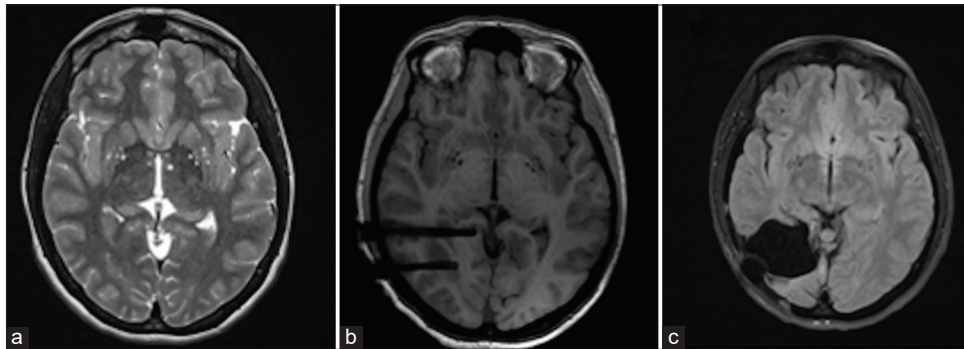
Forty-one-year-old patient with epilepsy for 26 years consisting of complex partial seizures and secondarily generalized with temporal semiology. (a) Axial presurgical brain magnetic resonance imaging (MRI) scan showing dysplasia (arrow) in the right occipito-temporal region. (b) Axial cerebral MRI section showing the arrangement of the depth electrodes. (c) Axial postsurgical brain MRI section showing right occipito-temporal regional resection. After surgery, the patient was free of crisis (Engel Class I). Postoperatively, she becomes hemianopic.
